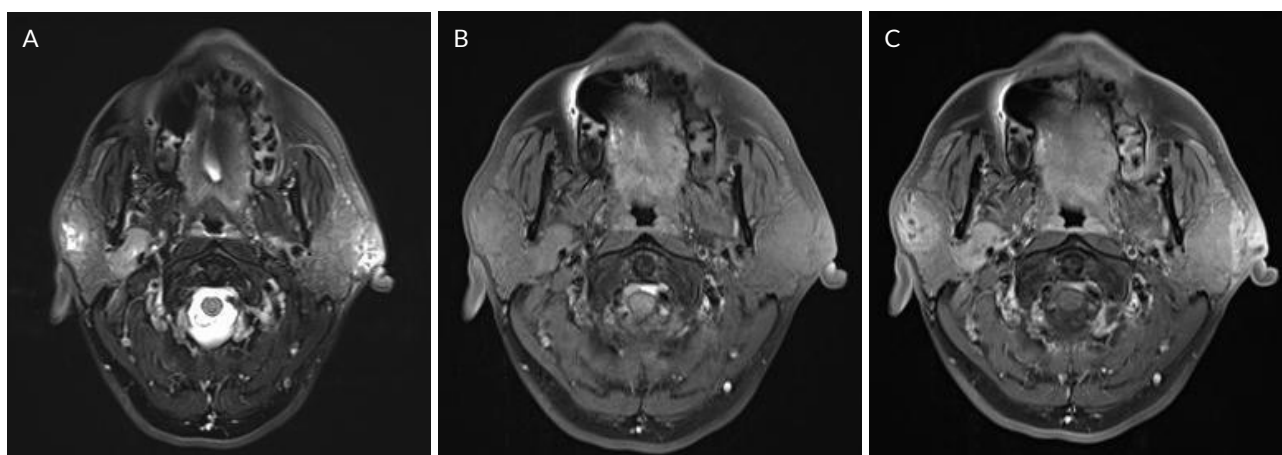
Magnetic resonance imaging of A) T2, B) axial pre-contrast and C) axial post-contrast soft tissue.
